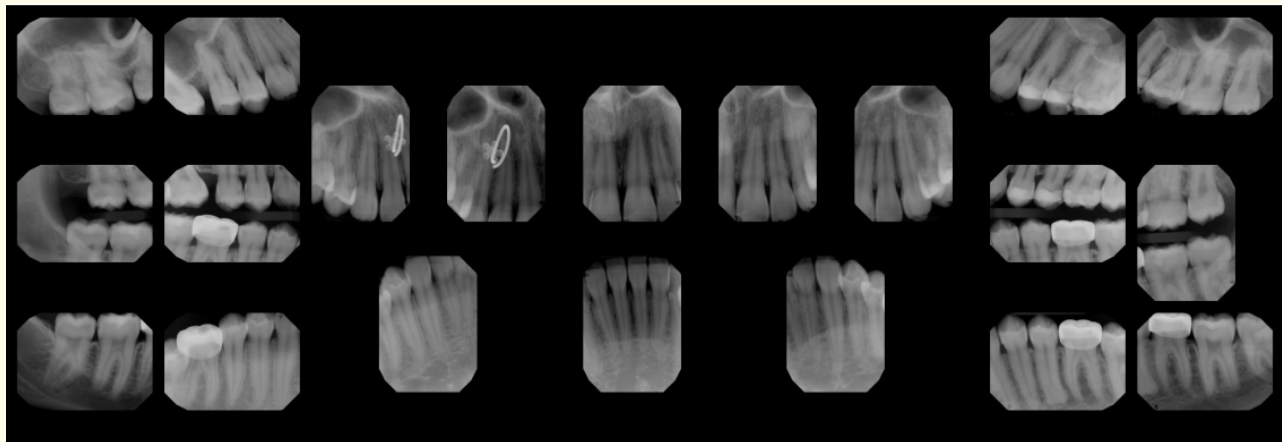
Full Mouth Radiographs
